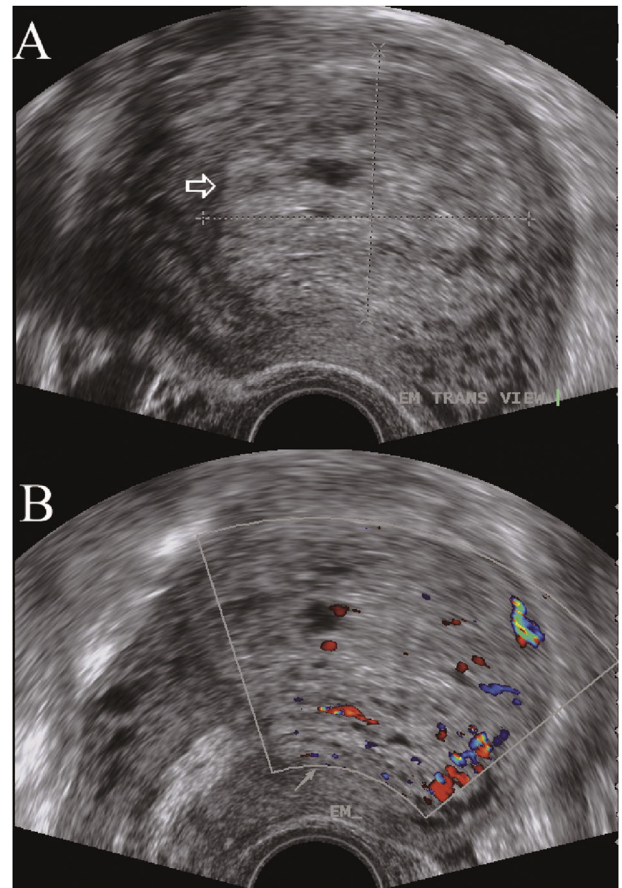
Ultrasonography at 2 weeks *postpartum* showing (A) a heterogenous lesion 4.7 cm \times 10.6 cm (indicated by arrowhead) in the uterine cavity with (B) increased vascularity.
